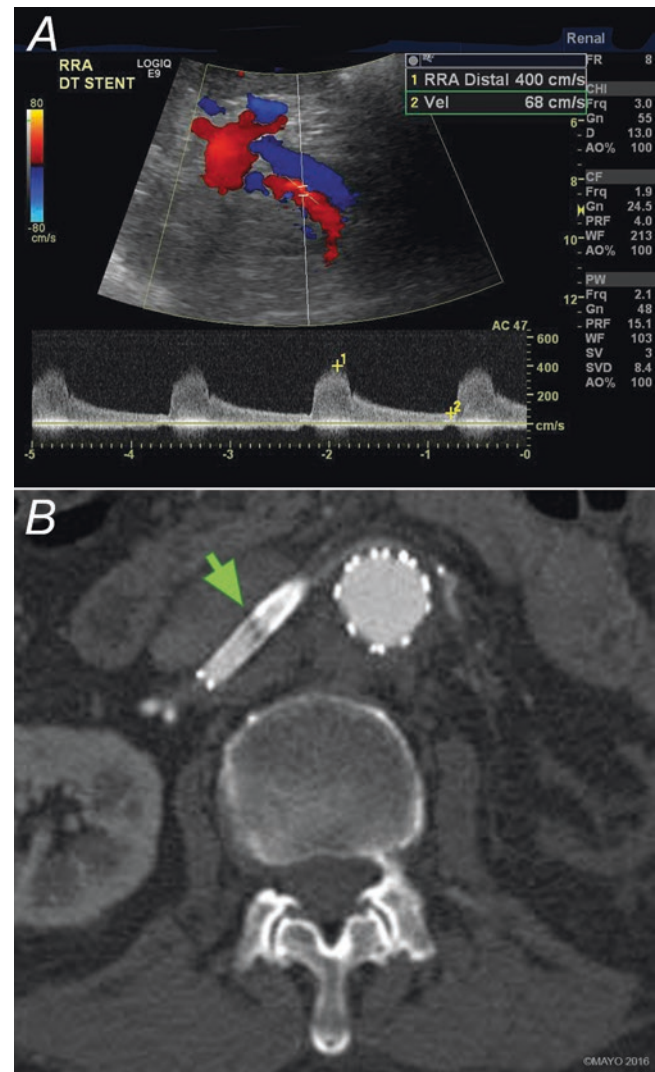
Duplex ultrasound and CTA of a right renal artery stent in a patient with fenestrated endograft. Elevated velocity in the distal right renal artery stent up to 400 cm/s (a) is indicative of recurrent in-stent stenosis. CTA demonstrates stenosis with filling defect (b, arrow) in the stent corresponding to the area of high velocity. By permission of Mayo Foundation for Medical Education and Research. All rights reserved
